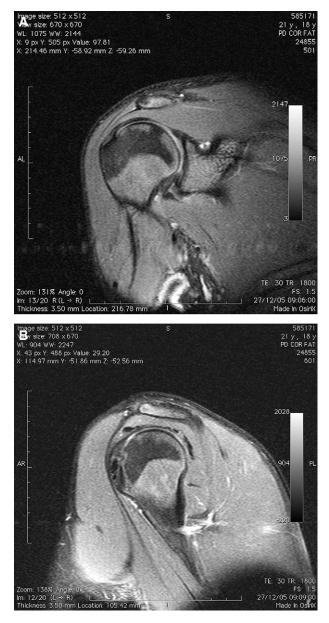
T2-weighted (A) oblique coronal and (B) oblique sagittal magnetic resonance images show a preserved acromiohumeral interval and anatomic integrity of the rotator cuff in a 19year-old patient.
